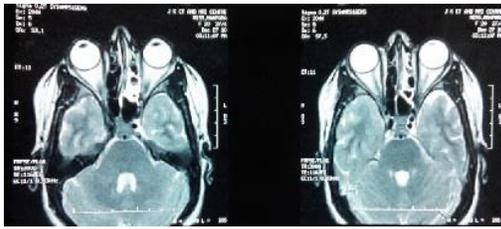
MRI Brain and Orbit showing normal study
